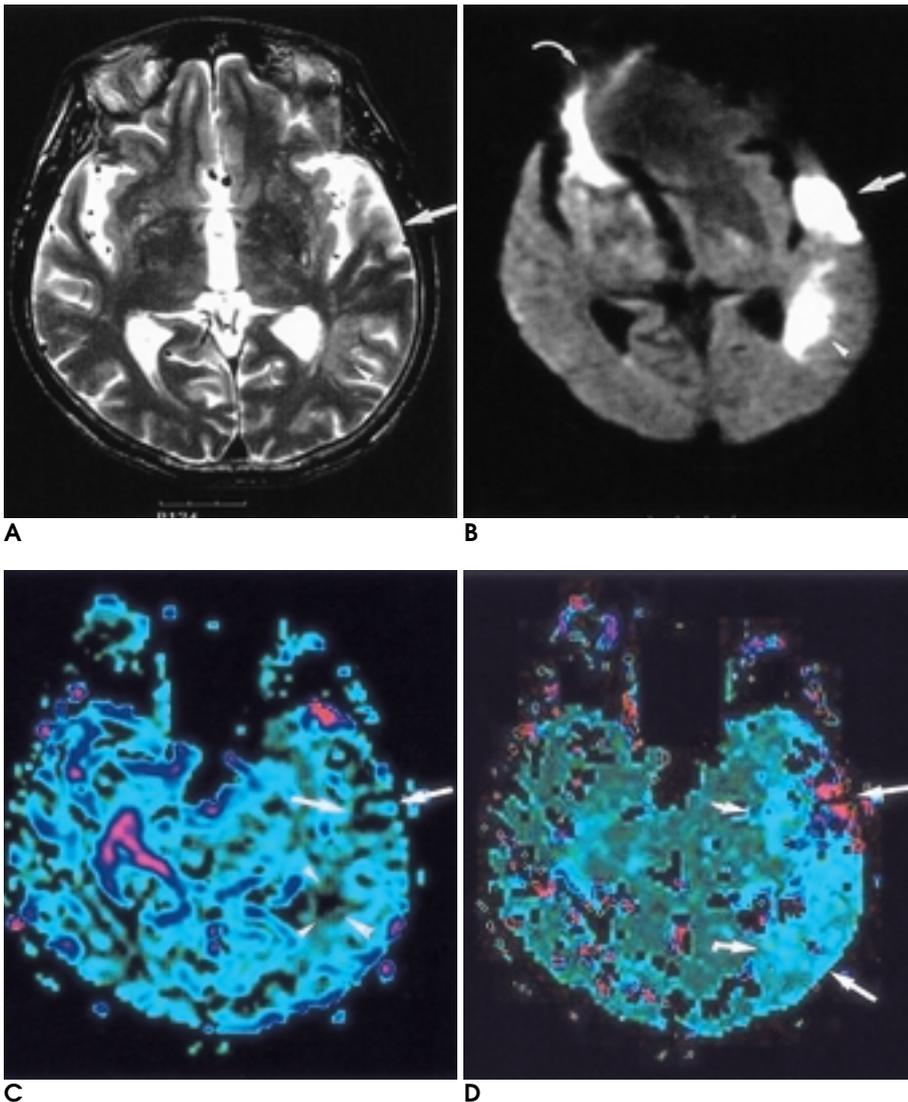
A 71-year old man with acute infarction. MR images were obtained 18 hours after symptom onset.
